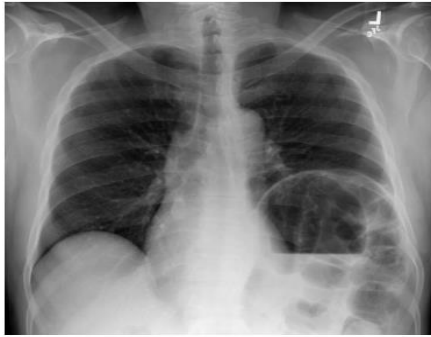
Example of diaphragmatic hernia in a chest X-ray image (NIH ChestX-ray14 dataset). Dataset.
